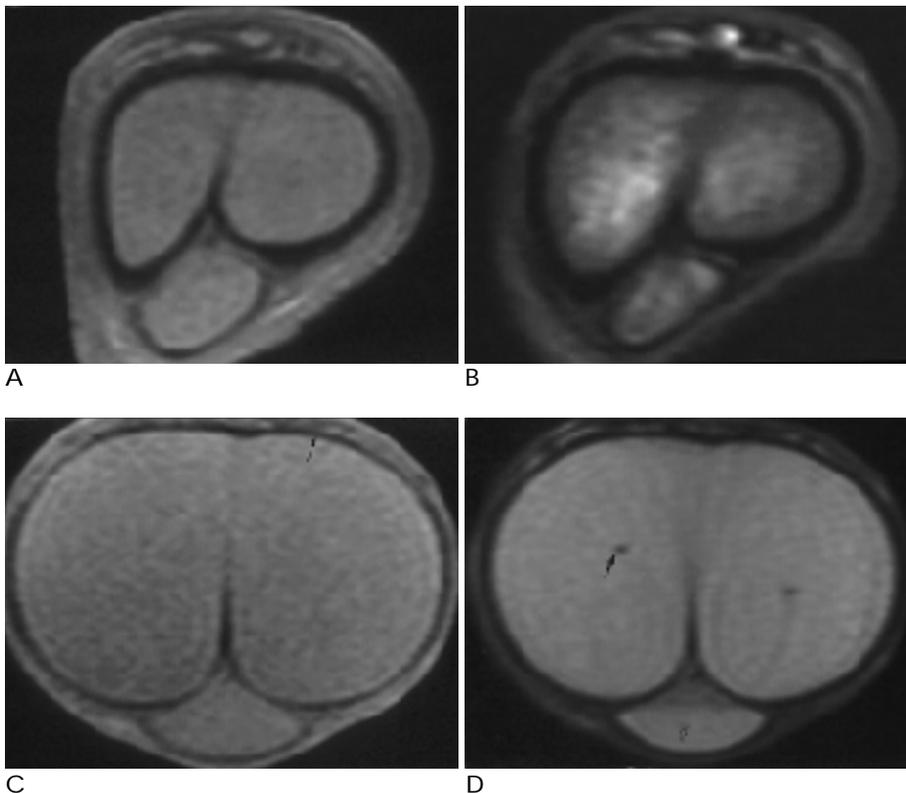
Coronal MR images of a normal penis in a 32-year-old man. A, B. Pre-erectile T1-weighted (308/12) (A) and T2-weighted (2200/70) (B) MR images show poor demarcation of penile structures compared with post-erectile MR images (C, D). In pre-erectile T2-weighted image (B), corpus cavernosa have heterogeneous signal intensities. C, D. Post-erectile T1-weighted (308/12) (C) and T2-weighted (2200/70) (D) MR images show the smooth thin tunica albuginea (thin arrow) with low signal intensity and corpus cavernosa with homogeneous medium and high signal intensities. Small deep artery of penis (thick arrow) and the urethra (open arrow) are well visualized in post-erectile T2-weighted image (D).
